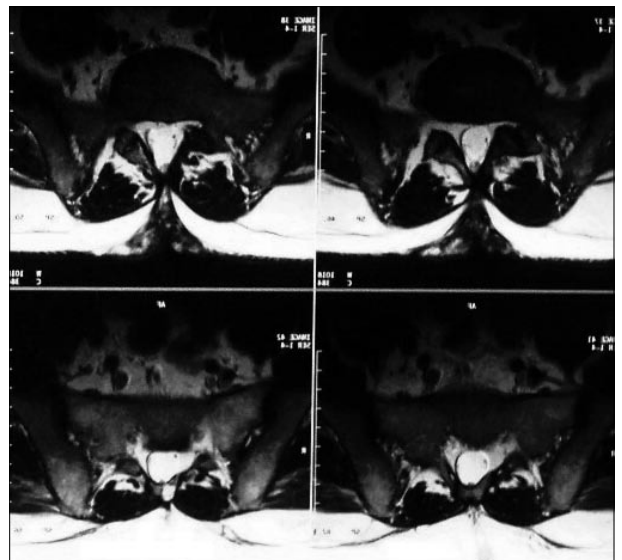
Axial T2-weighted MR images demonstrated associated lipoma and no neurological tissue involved in the meningocele cavity.
